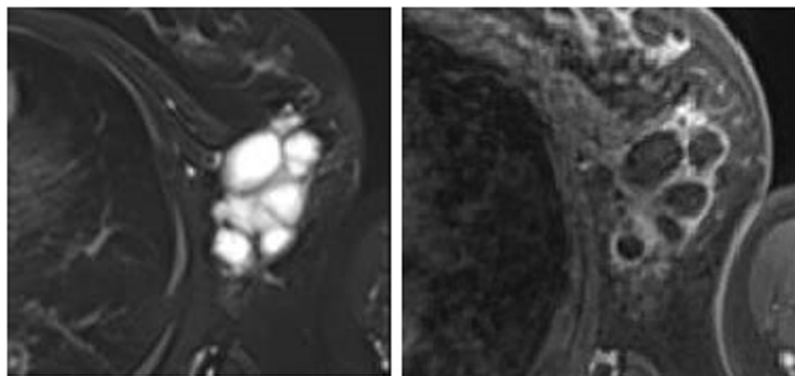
Magnetic resonance imaging (MRI). Left: High-intensity MRI of internal spaces on the T2-weighted image. Right: Enhancement of wells, surrounding walls, and internal septa on the T1-weighted dynamic image.
